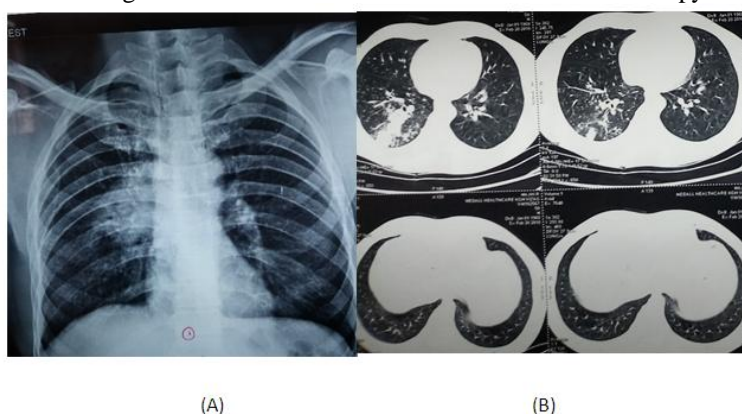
RADIOLOGY- (A) CHEST X-RAY PA VIEW, (B) CT CHEST LUNG WINDOW Showing resolution after 4 months of oral fluconazole therapy.
